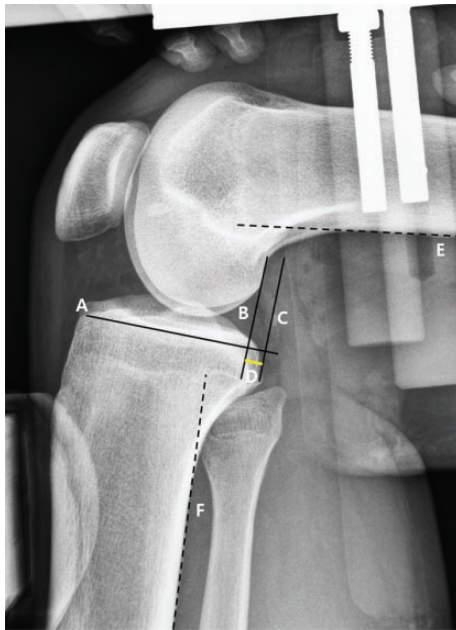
Measurement of posterior tibial displacement on posterior stress radiograph at a knee flexion angle (KFA) of 90°. Perpendicular lines from the reference line (solid black line A, parallel to the medial tibial plateau joint line) are drawn tangentially to the midpoint between the most posterior contours of the medial and lateral femoral condyles (solid black line B) and medial tibial plateau (solid black line C). If the femoral condyle is in an inappropriate rotation position, the midpoint between the most posterior contours of the medial and lateral femoral condyles is used. The distance between lines B and C is defined as the posterior tibial displacement (D, yellow line). The KFA is defined as the angle between the extension of the distal femoral posterior cortical line (dashed black line E) and the proximal tibial posterior cortical line (dashed black line F).
